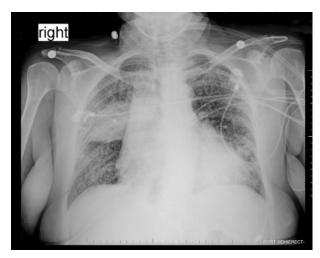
Chest radiograph at hospital presentation shows miliary opacities, wide mediastinum, and a right upper lobe process suggestive of disseminated tuberculosis.
